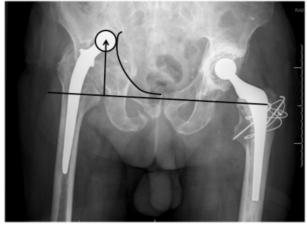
Radiograph demonstrating pre-operative acetabular deficiency and migration of femoral head (A) relative to Kohler's line (B) and inter-teardrop line (C).
